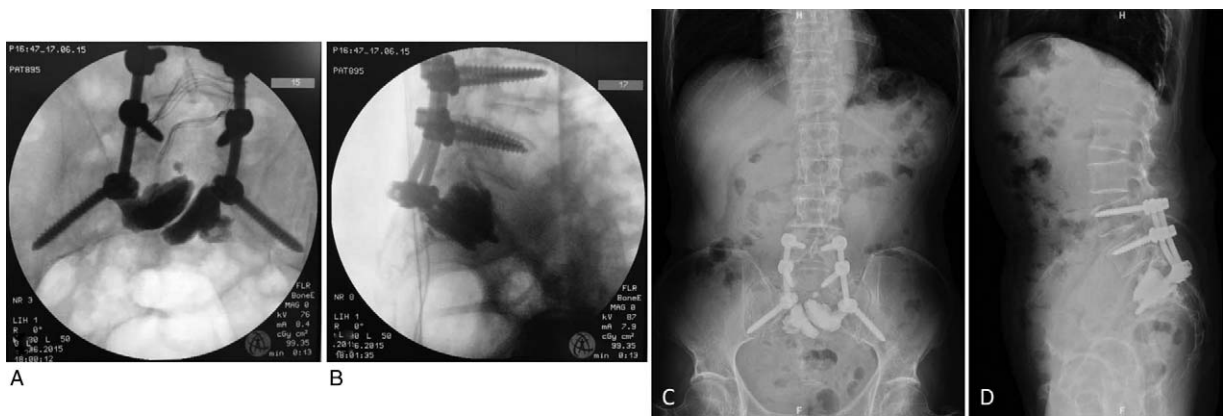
(A, B) Visual inspection using the intraoperative fluoroscopy showed optimal position of all pedicle screws. (C) Posteroanterior (PA) x-ray image of the sacrum obtained postoperatively. (D) Lateral x-ray image of the sacral spine obtained postoperatively.
